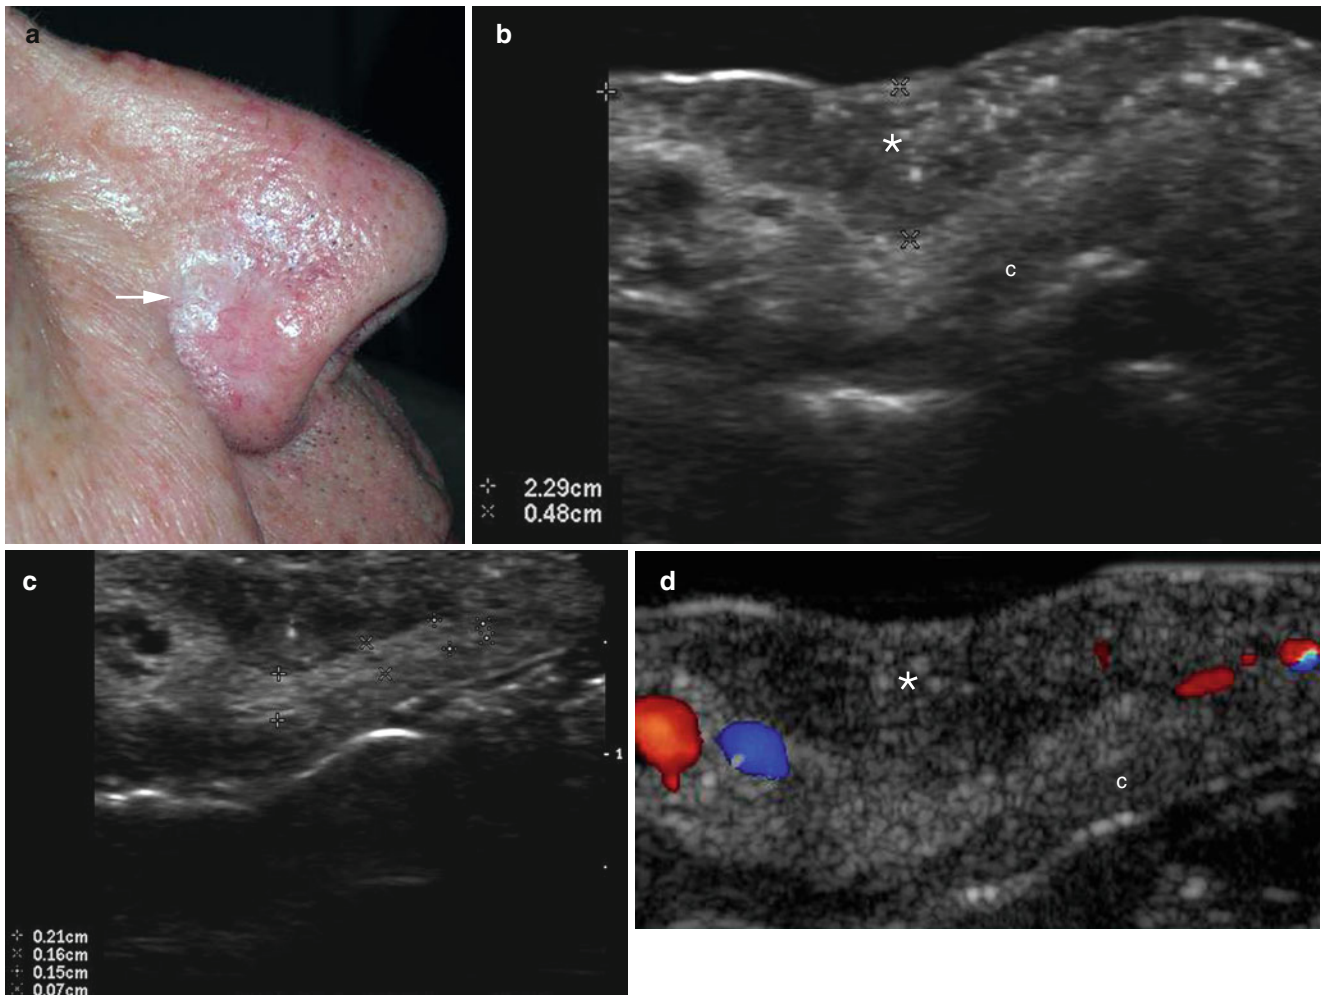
(a–g) Morpheaform basal cell carcinoma. (a) Clinical image shows a pearly and erythematous nodule (*arrow*) in the right nasal wing. (b, c) Grey scale ultrasound images (transverse views; b superficial and c deep focus) demonstrate a 2.29 × 0.48 cm well-defined fusiform hypoechoic lesion located in the dermis and upper subcutaneous tissue. Notice the multiple hyperechoic spots within the lesion and the tapering of the distance (0.21–0.07 cm going from the posterior to anterior aspect) between the tumor and the right nasal cartilage (c).
